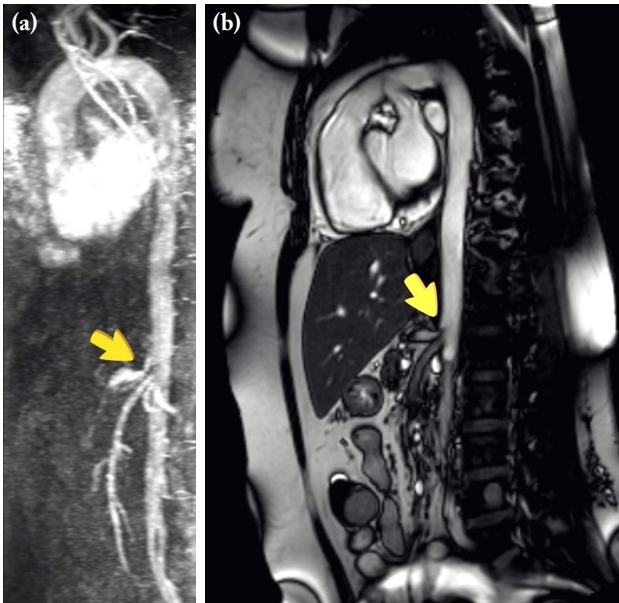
(a) Severe stenosis and poststenotic dilatation of the celiac artery in computed tomography angiography (yellow arrow); (b) severe stenosis and poststenotic dilatation of the celiac artery on magnetic resonance imaging (yellow arrow).
